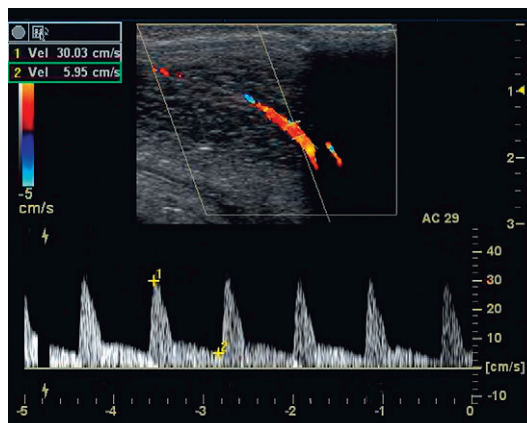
Spectral Doppler tracing of venous insufficiency. Relatively high velocity persistent forward flow is seen during diastole (approximating 6 cm/sec). This despite appropriate arterial inflow velocities.
